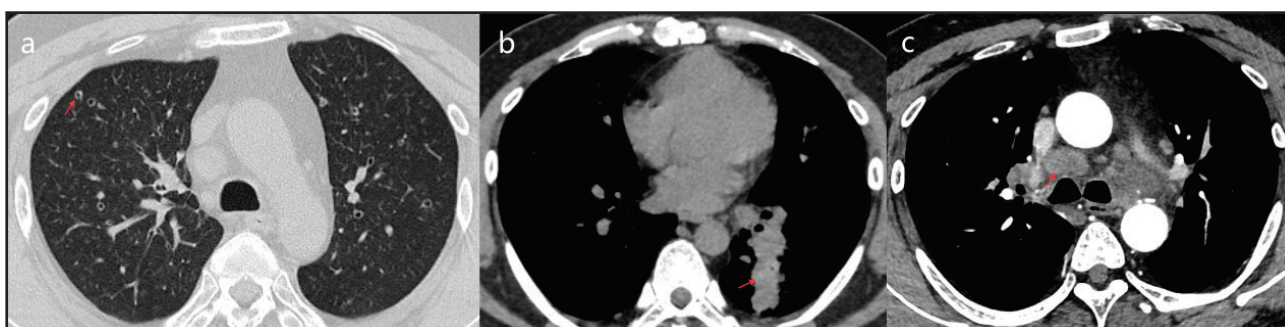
Baseline chest CT. (a) Lung window showing widespread bilateral multiple thin-walled cystic lesions. (b and c) Mediastinal window showing a left lower lobe mass and mediastinal lymphadenopathy.
